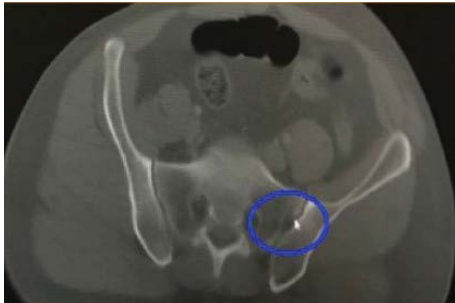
Axial computed tomography section image of the semicircular defects variation at the S1 vertebral level in the sacral bony in a 40-year-old man patient.
